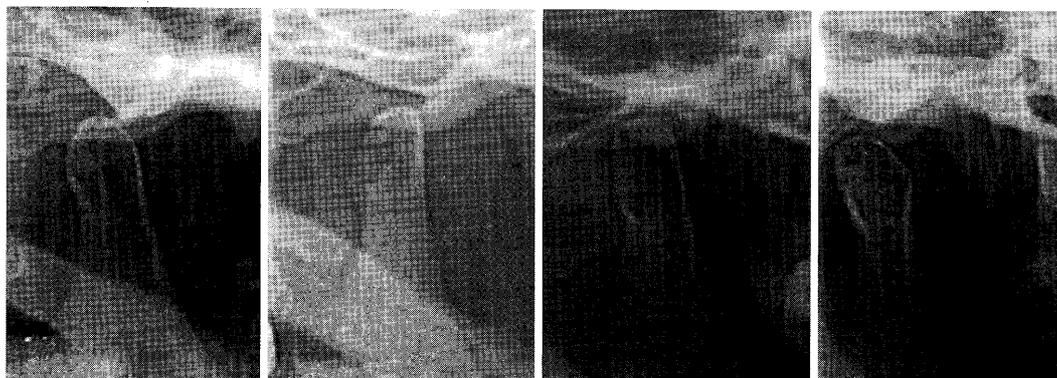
Classification of mandibular condyle morphology (X-ray)
